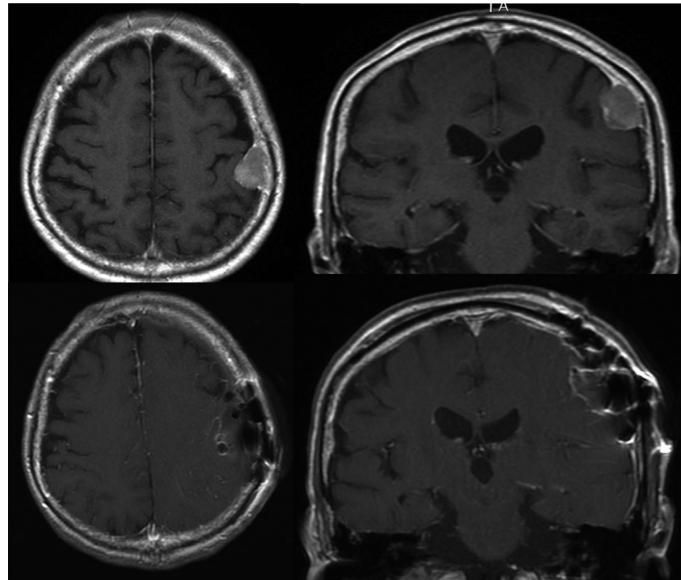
Axial and coronal MRI with contrast enhancement before and after surgery. Axial (Panel 1) and coronal (Panel 2) MRI with contrast enhancement (Panel A, before surgery; Panel B, one week after surgery) shows brain tumor located in the left S1 of IPL, which was totally removed.
